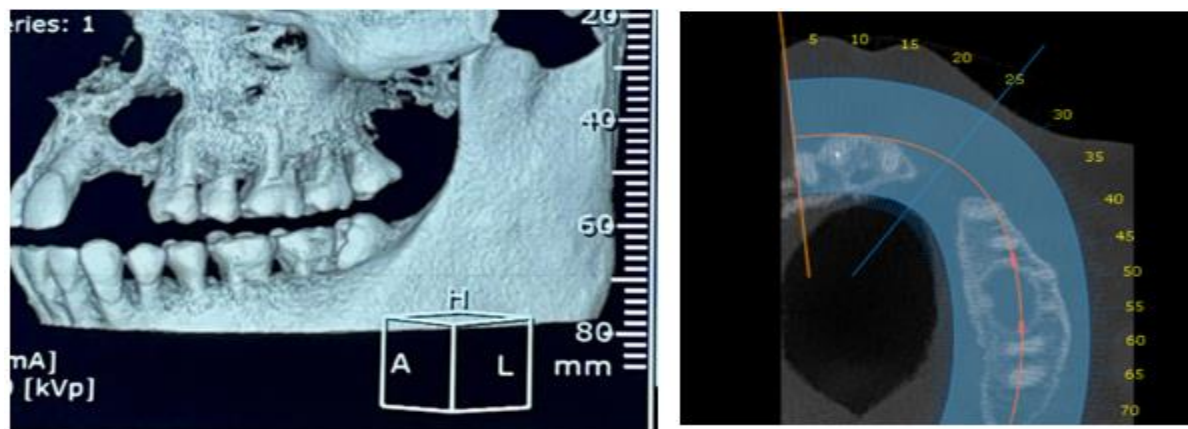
CBCT images showing the defect in 3d imaging and axial section.
